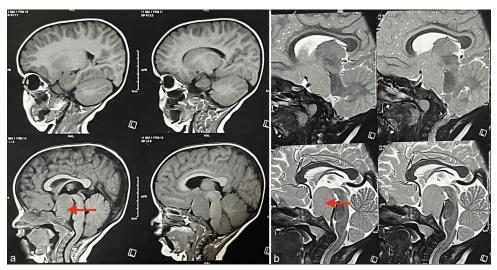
A 3-year-old girl with Pallister-hall syndrome who presented with short stature. (a) Magnetic resonance imaging brain T1-weighted images show a large hypothalamic hamartoma (arrow) isointense to gray matter. (b) T2-weighted images show the same mass (arrow) which is isointense to gray matter and measures $3.1 \times 2.5 \times 3.4$ cm.
